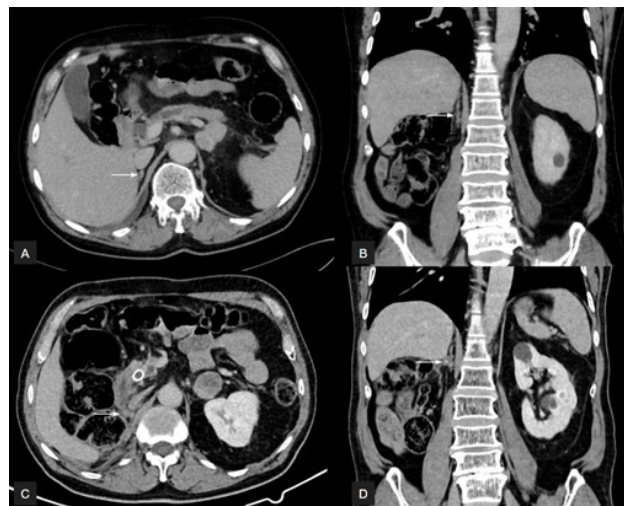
Abdominal venous phase CT images obtained one year apart. A and B were obtained when the patient presented in the emergency department (A - axial, B - coronal) and C and D were obtained one year later (C - axial, D - coronal). These images show a small lesion in the right nephrectomy site (white arrows) showing growth one year later, suggestive of local tumor recurrence.
